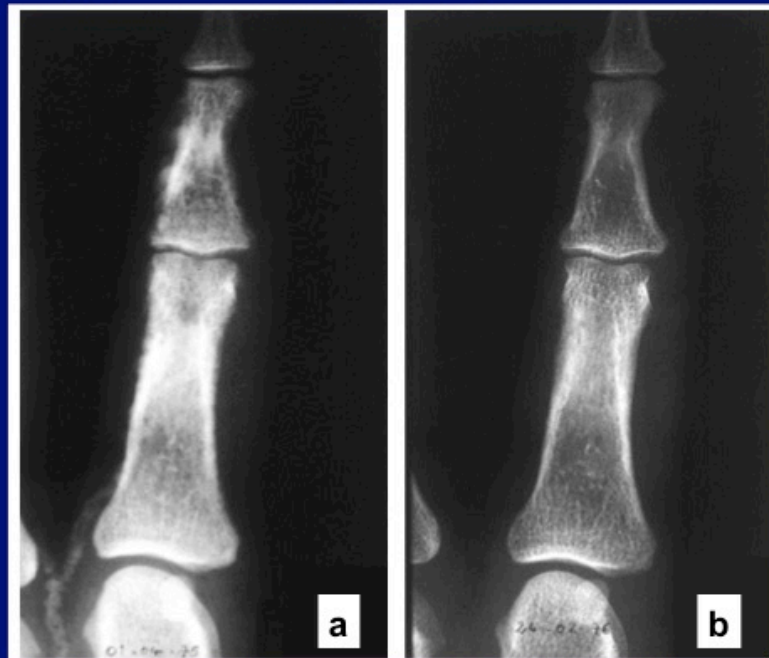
(a) X-ray aspect of periosteal resorption within cortical bone of middle phalanges of the hand, indicative of osteitis fibrosa, and extensive finger artery calcification in a CKD stage 5 patient with severe secondary hyperparathyroidism. (b) Aspect one year after surgical parathyroidectomy (PTX): complete bone lesion healing and disappearance of arterial calcifications.
